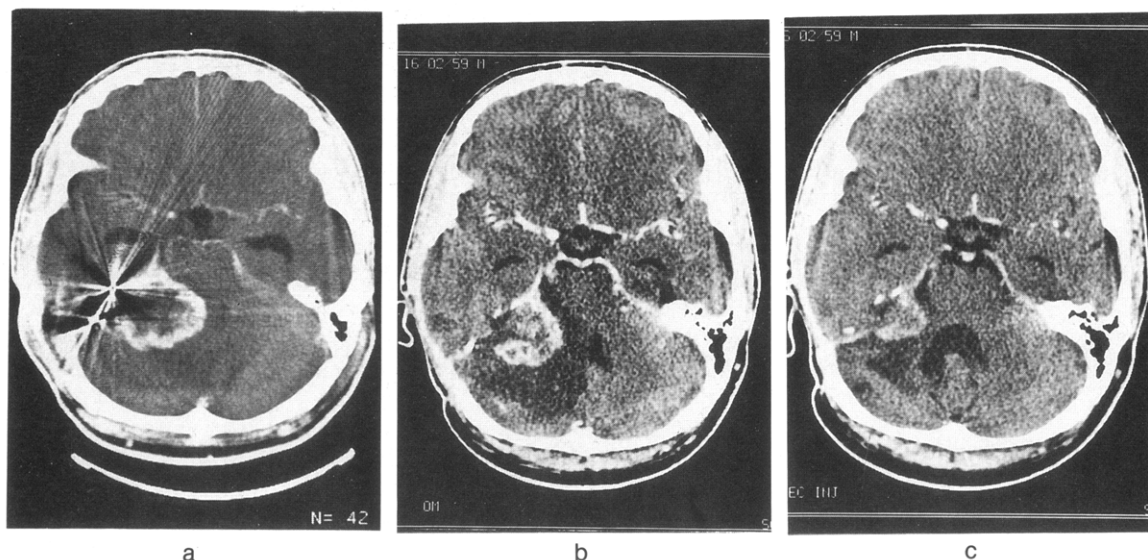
A case of tumor regression in a 30-year-old man who underwent partial removal of a right Stage IV neurinoma (Case 9); (a) postoperative CT scan showed a residual mass; (b) 1 year later, tumor decreased in size; (c) 3 years later, tumor regression was greater than 50%.
